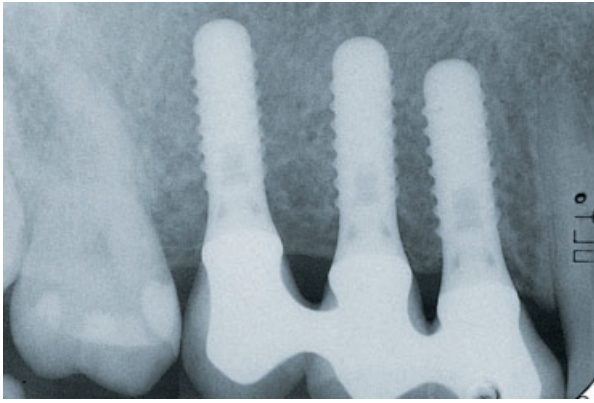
The corresponding follow-up radiograph confirms acceptable peri-implant conditions.
